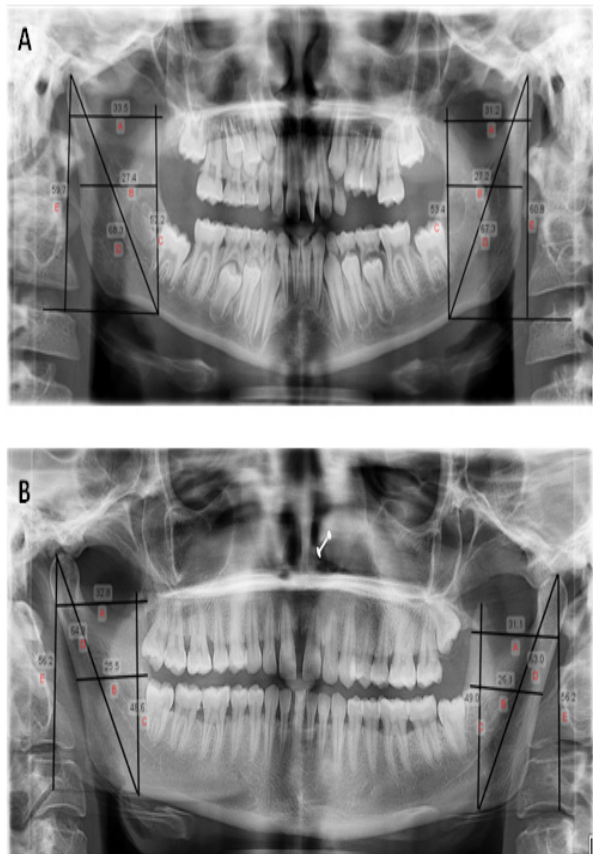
Measurement of mandibular parameters on orthopantomogram in a) male and b) female.
